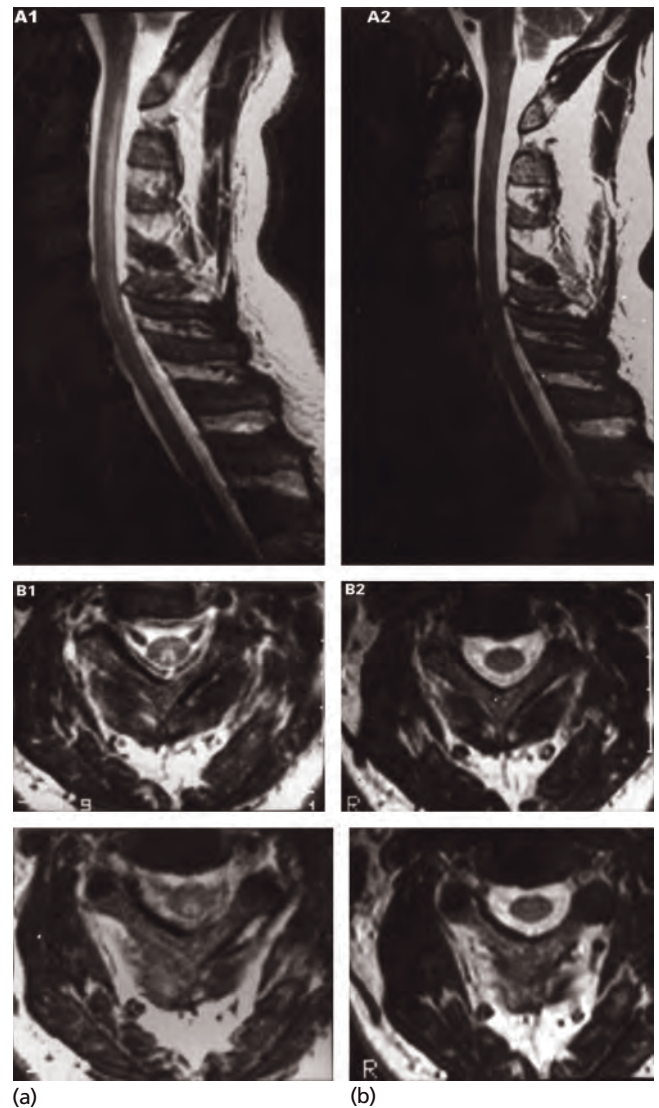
Subacute combined degeneration of the cord. On admission (a) and after initiation of cobalamin treatment (b). The hyper-intense lesions of the posterior column disappeared after treatment. (MRI T2W.) (From Hemmer *et al.* 1998, with permission.)
